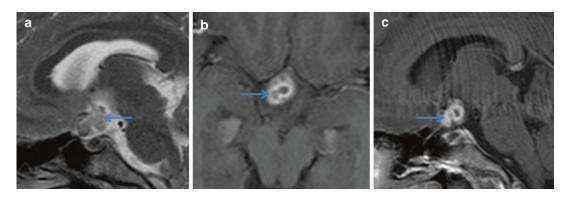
Optochiasmatic tuberculomas in a young female. Mid sagittal T2WI (a), post-contrast T1-weighted fat-suppressed axial (b), and midsagittal (c) images show
